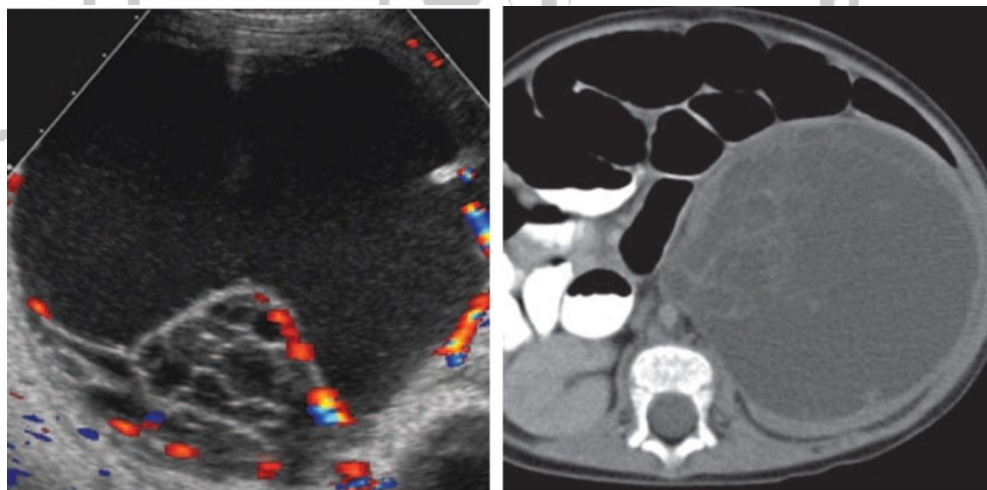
Multilocular cystic nephroma. Right , Transverse ultrasound image of left kidney shows cystic mass with echogenic septa. Bloodflow within these echogenic septa is also seen. Left, Contrast-enhanced axial CT image shows large water-attenuation mass with well circumscribed borders and mildly enhancing internal septations.
